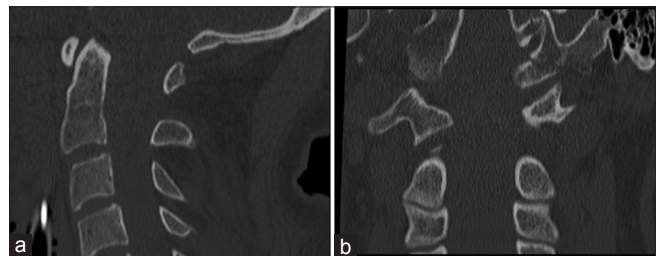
Computed tomography of the C spine demonstrates atlanto-occipital dislocation: (a) sagittal, (b) coronal
